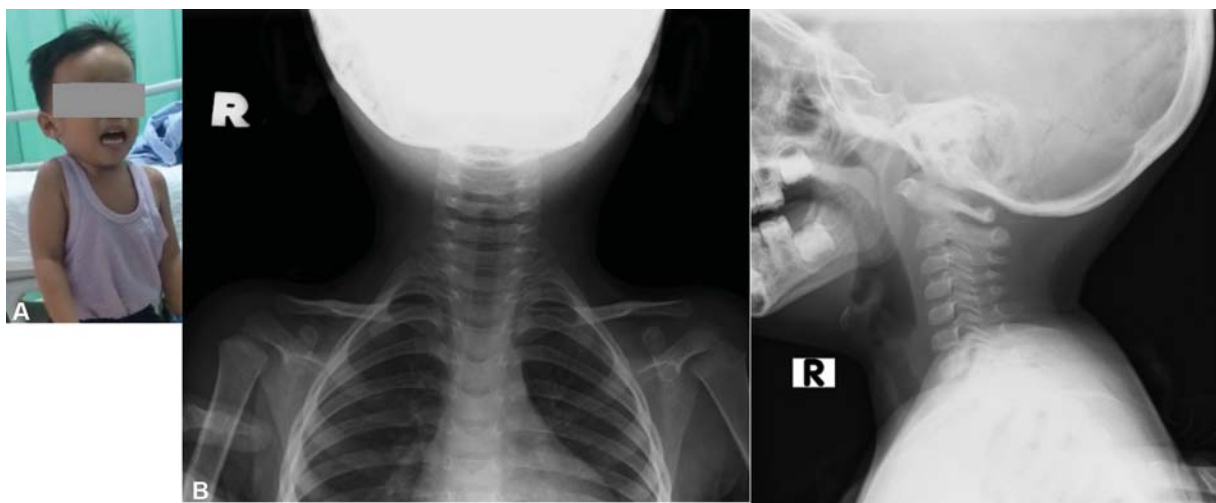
(A) Clinical image showing the patient with an anomalous head position known as cock-robin head position. (B) Initial anteroposterior and lateral radiograph of the neck revealed no overt abnormalities.
